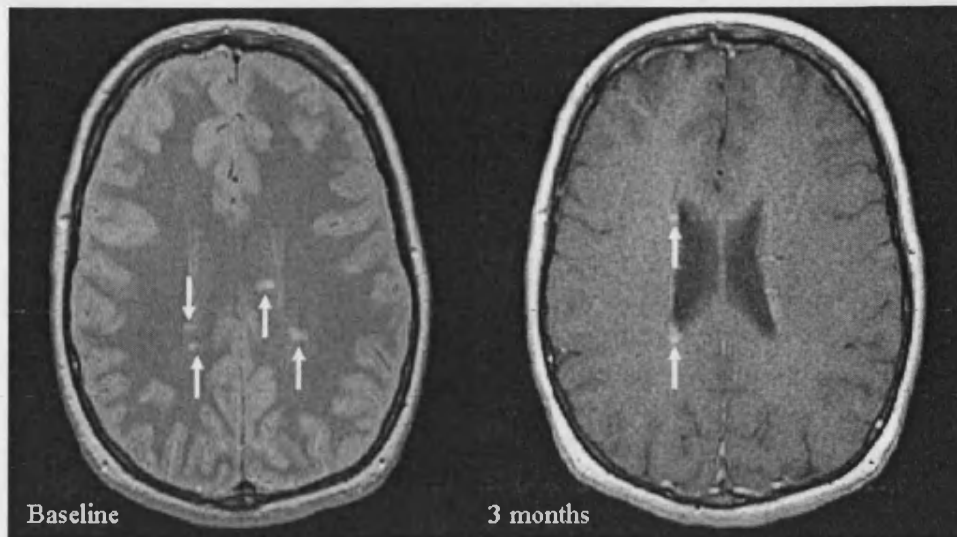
Left - baseline proton density weighted FSE MRI (left) of a 37 year-old woman with left optic neuritis demonstrating asymptomatic brain lesions (arrowed). Right – gadolinium-enhanced T<sub>1</sub>-weighted spin echo image taken three months later demonstrating two new enhancing lesions (arrowed) sufficient to give a diagnosis of MS using the McDonald criteria.
